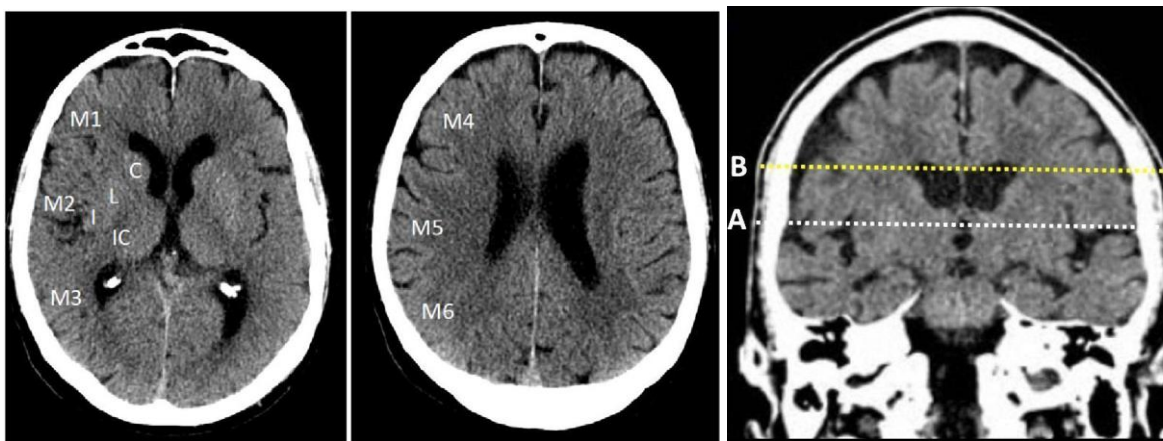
Alberta Stroke Program Early CT Score (ASPECTS) scoring scheme with cut levels on coronal image
